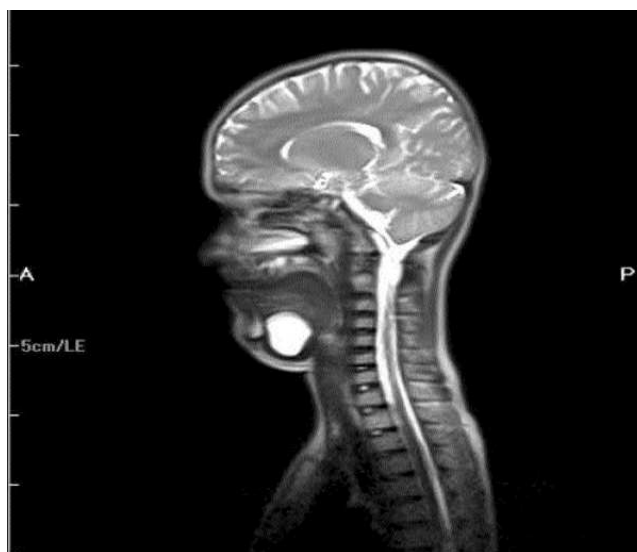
Preoperative MRI scans showed 40 × 30 mm well-circumscribed non-enhancing cystic mass extending in submental and sublingual area.
